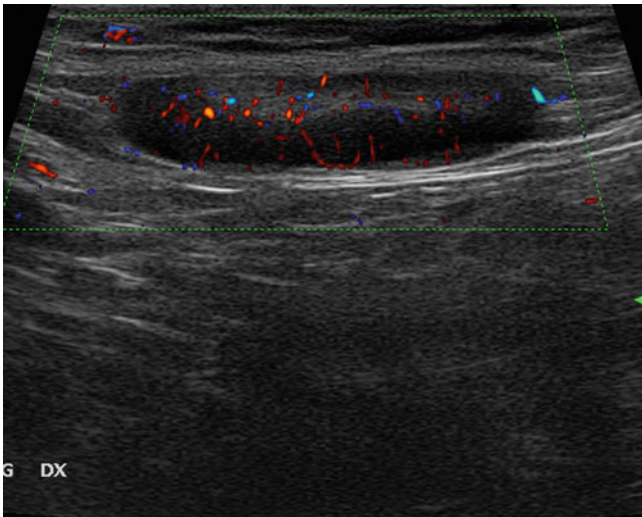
Lymph-node metastasis. Inguinal lymph node with diffuse but asymmetric cortical thickening and multiple peripheral flow signals using directional power Doppler imaging. Despite its elongated shape, the lymph node proved to be metastatic at surgery
